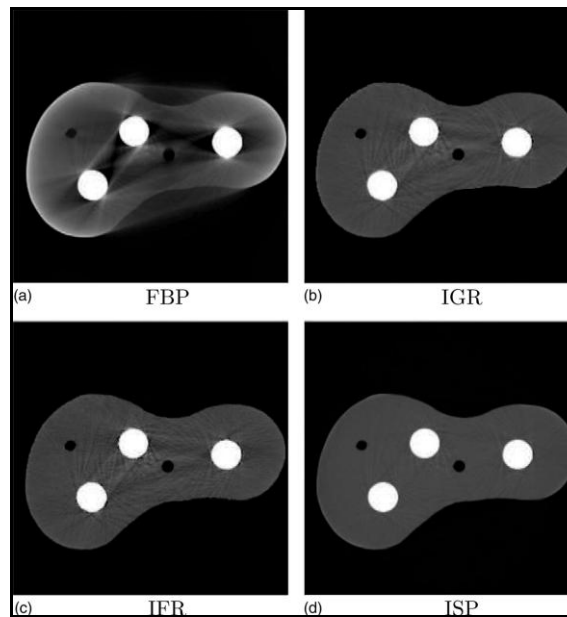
Reduction of beam hardening artefacts through iterative reconstruction in CT. FBP: filtered backprojection. IGR: FBP-based optimisation. IFR: Gradient based optimisation. ISP: Sinogram pre-processing method. From Van Gompel *et al* 2011.
